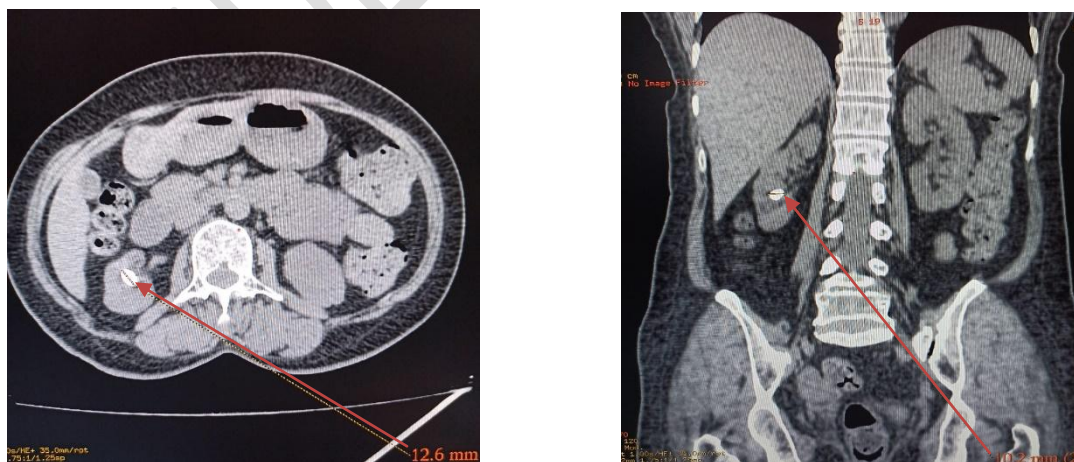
CT KUB (plain) showing right lower calyx stone.
